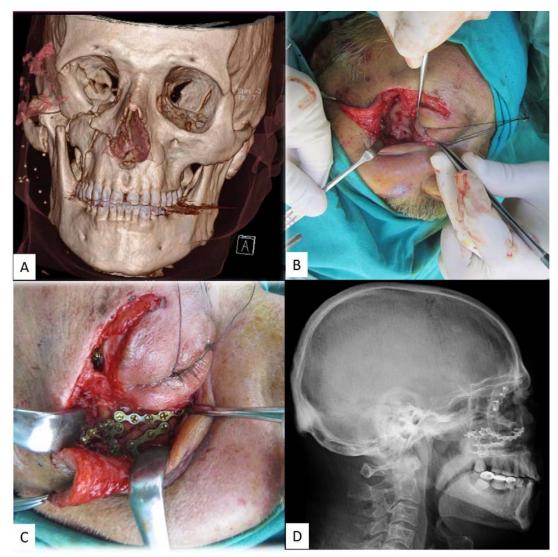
(A) Preoperative 3D computed tomography appearance of the maxillofacial fracture. (B) Appearance after intraoperative exploration. (C) Intraoperative appearance after internal fixation. (D) Postoperative X-ray appearance of the early result.
